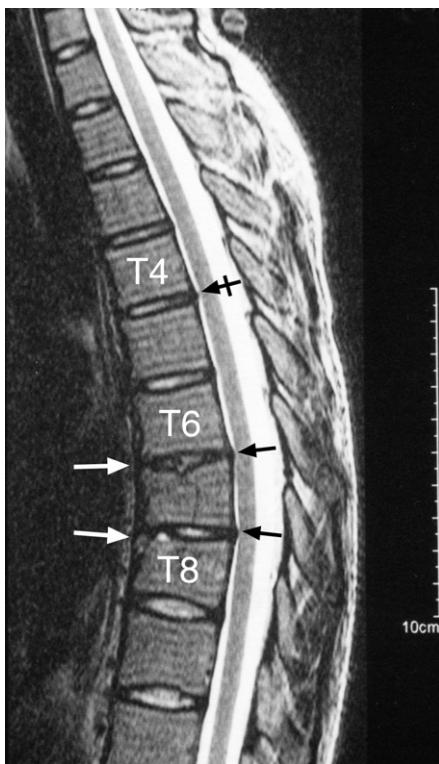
Thoracic spine MRI sagittal T2-weighted image. Note the 'wedge compression fractures involving the superior end-plates of T7 and T8', the traumatic 'degenerative narrowing (white arrows) and signal loss involving the T6–7 and T7–8 intervertebral discs associated with minimal central posterior disc bulges (black arrows) ... and slight angular kyphosis at the level of the compressed vertebral bodies'. In addition, the T4–5 intervertebral disc shows early desiccation with a minimal central posterior disc bulge (tailed black arrow). These disc bulges press on the pain sensitive anterior part of the thecal sac and, due to the slight angular kyphosis, appear to be causing the T6–7 and T7–8 disc bulges to be in close proximity to the spinal cord.
